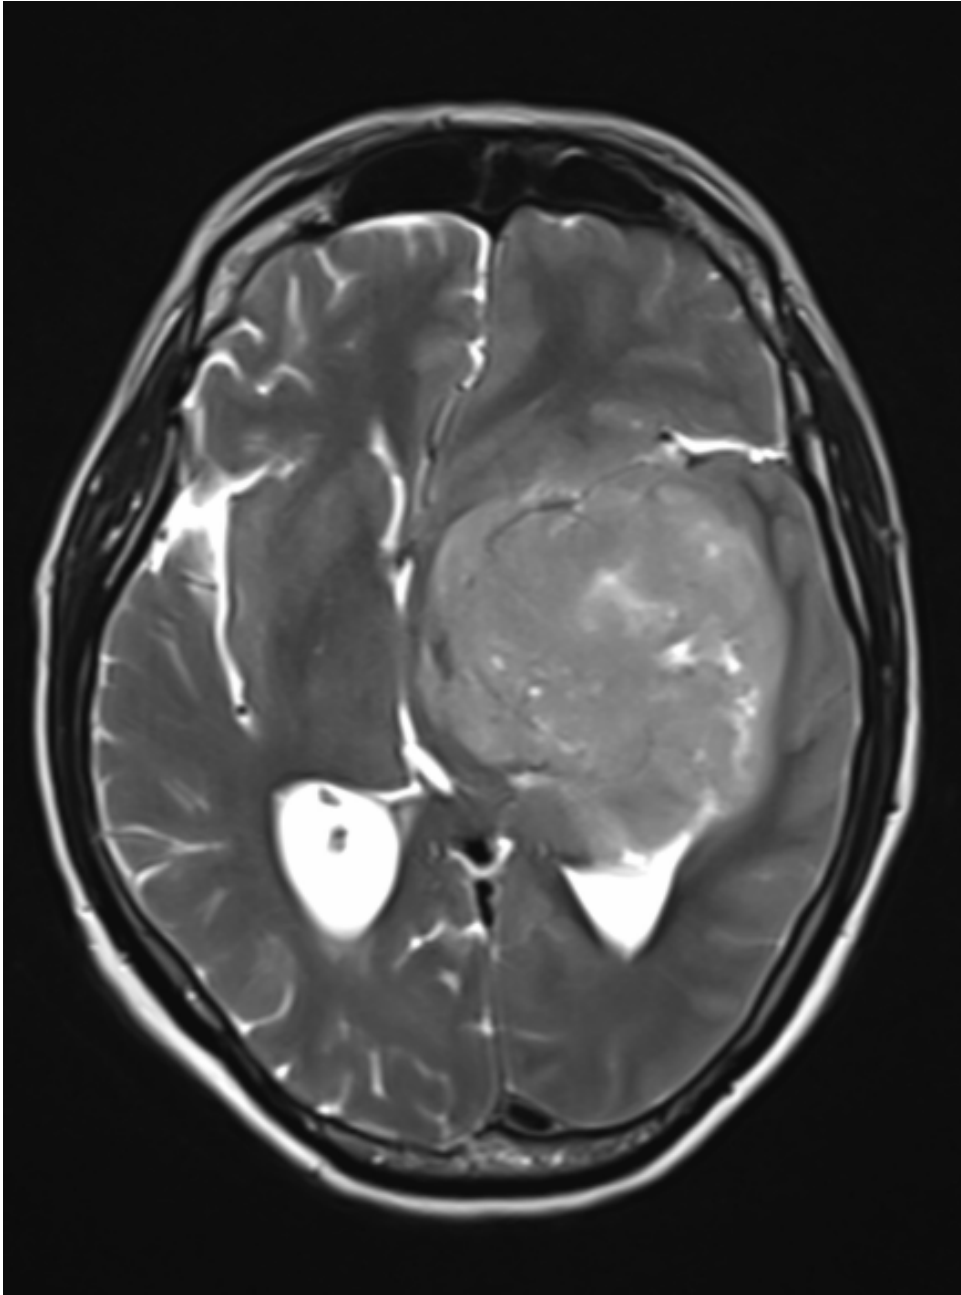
MRI brain – S1527/19, Parietal glioblastoma (IDH1 & EGFR negative) – ring enhancement absent
